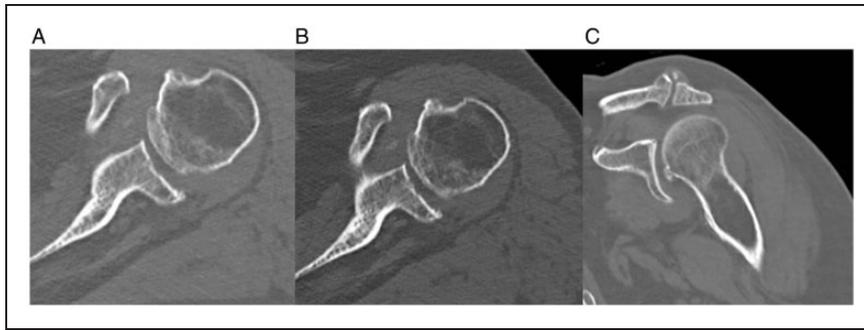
A and B, Axial CT images. C, A coronal CT image calibrated to a bone window demonstrating superior and anterior migration of the humeral head with arthritic changes of the glenohumeral and acromioclavicular joints including a large osteophyte in the glenohumeral joint and subchondral cystic changes with intraarticular loose body (B).
